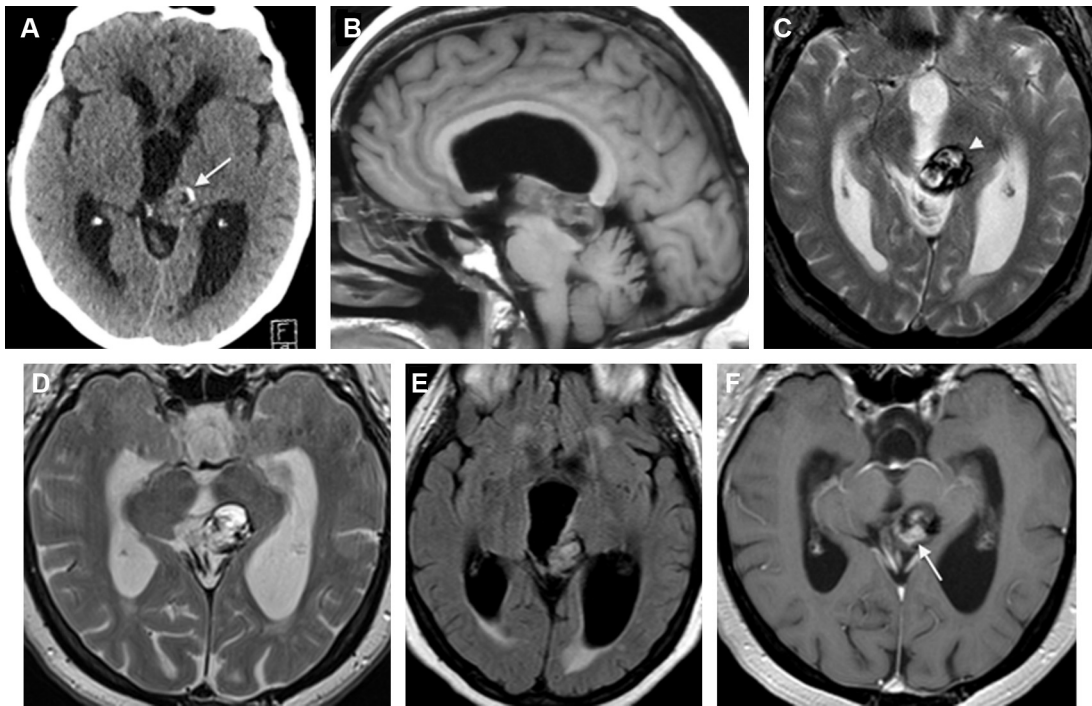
A. Axial CT scan showed a deformation of the posterior part of the third ventricle with intralesional hemorrhage (arrow head). B. MRI sagittal T1: left posterior thalamic exophytic lesion (into the third ventricle) with quadrigeminal mass effect. C. Axial gradient echo T2 MRI: the lesion was multilocular with calcifications (arrow). D. Axial T2 MRI: left posterior thalamic exophytic lesion with supratentorial ventricular dilatation. E. Axial flair MRI: the hypersignal along the wall of the 3rd ventricle did suspect the intraventricular dissemination. F. The lesion presented heterogeneous contrast enhancement (arrow head) after gadolinium injection in the axial T1 enhanced.
